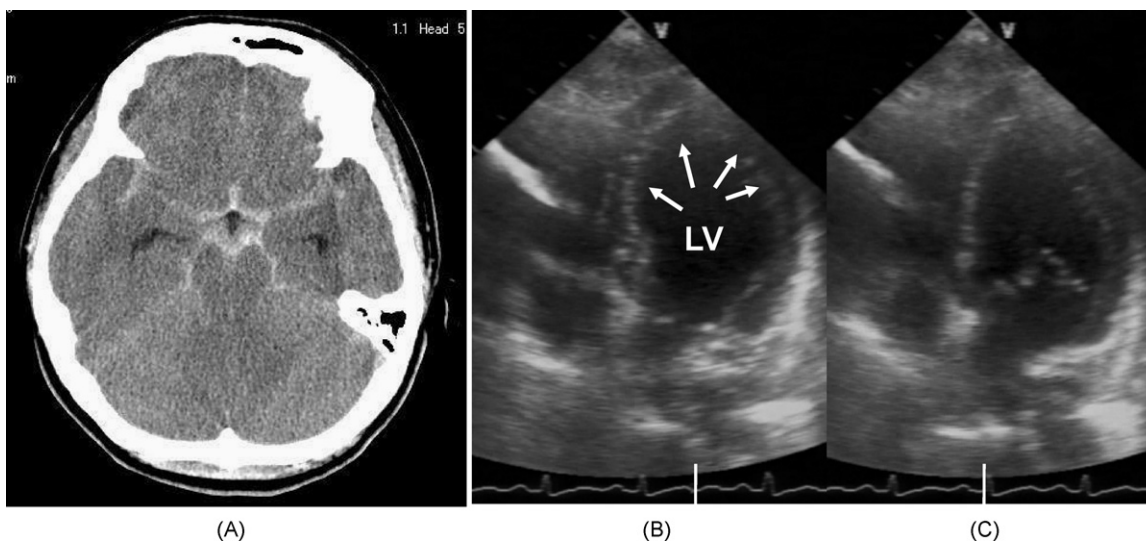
Computed tomography (A), and echocardiogram of end systole (B) and end diastole (C) of the presented patient. Extensive subarachnoid hemorrhage with bilateral intraventricular hemorrhage was observed on computed tomography (A). Akinesis of the left ventricular apex and mid segments (white arrows) was found on the apical 4-chamber view after resuscitation. LV, left ventricle.
